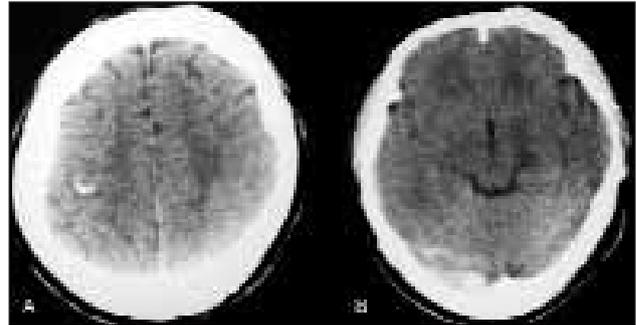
A The dense vein sign was seen on the right parietal cortical region on axial CT scan without contrast. B Hyperdense changes over right occipital region probably denotes to right transverse sinus on axial non contrast CT scans.
